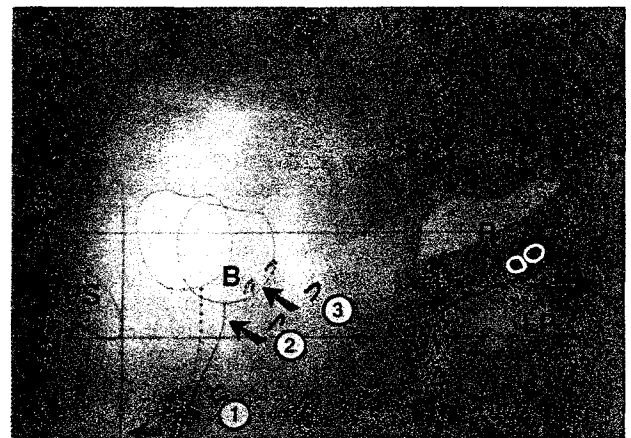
Vaginal stretching during squeezing. Same patient and labeling as Fig. 1. This represents a resting standing lateral X-ray superimposed on a squeezing X-ray in a normal patient. Compared to Fig. 1 the whole levator plate appears to have been lifted upwards and forwards (diagonal arrows), also elevating the bladder neck, vagina and rectum. Note similar forward movements of the midurethral part of the vagina (urethral closure mechanism).
